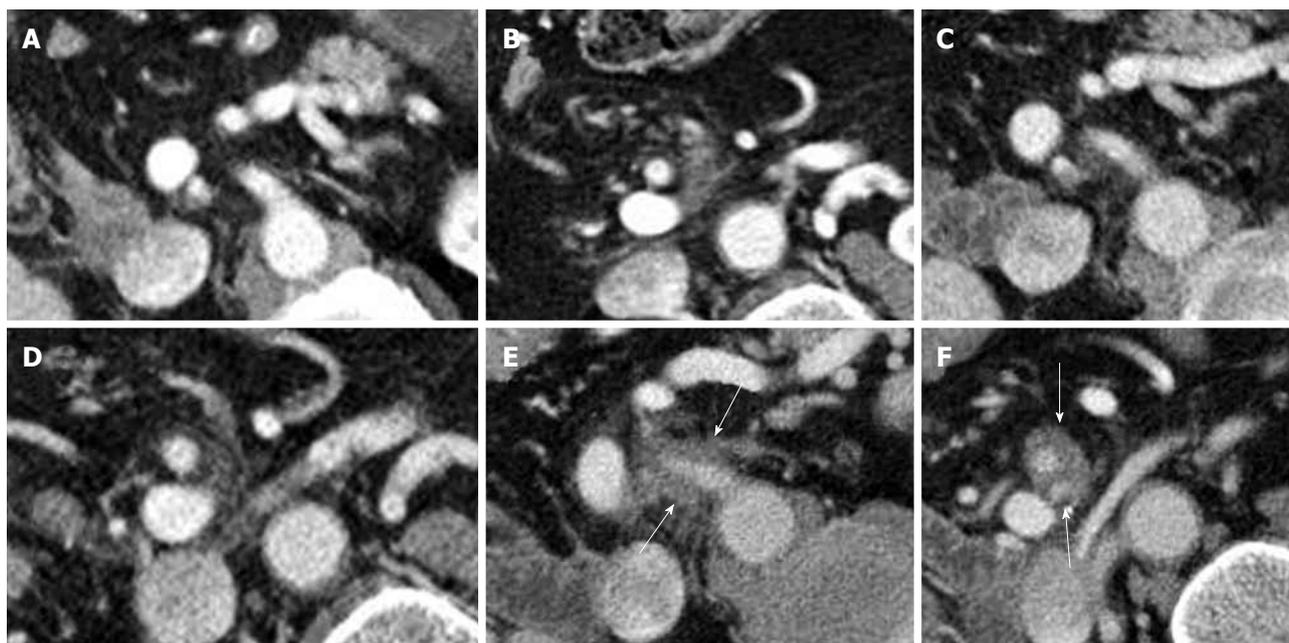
Computed tomography follow-up after Whipple's procedure for pancreatic cancer of the head in a 69-year-old patient (T3, N1). A, B: Follow-up imaging after 3 mo; C, D: 11 mo; E, F: 22 mo. Recurrence at the origin of the superior mesenteric artery (E) and more distally in the mesenteric root (F: white arrows).
